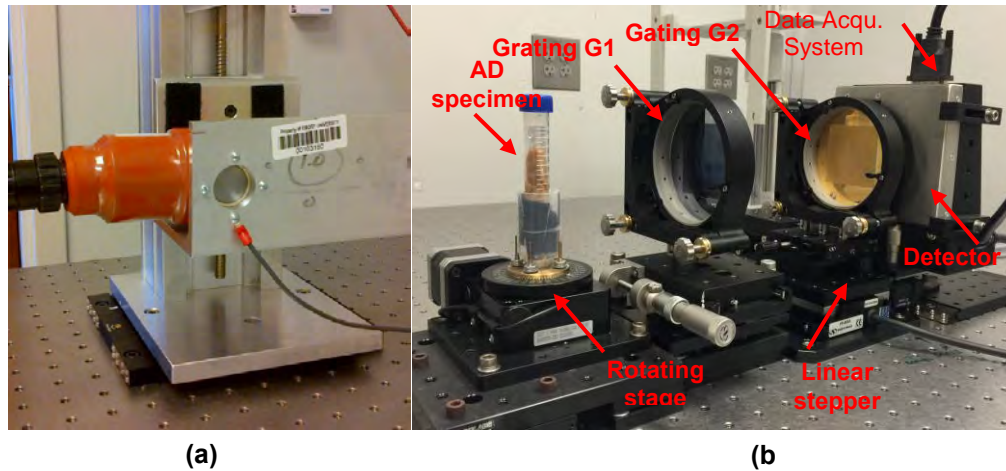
Pictures of the prototype x-ray phase CT system that is fully functioning in the PI's lab: (a) the micro focus x-ray tube and (b) the rest of the system, including rotating stage, grating G_1 , grating G_2 , linear stepper, flat panel x-ray detector and data acquisition system.
